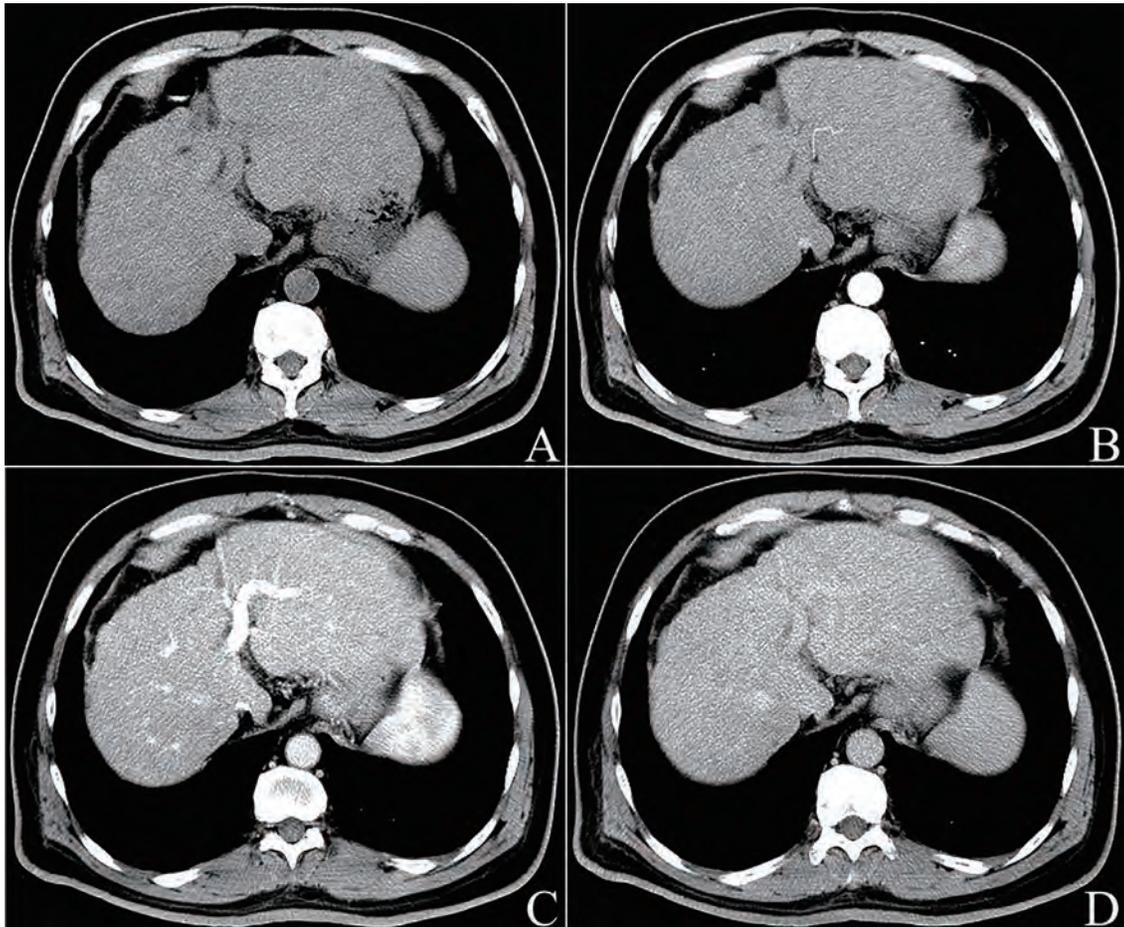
CT images of liver cirrhosis. Axial CT images show dysmorphism of the liver, including pronounced nodular irregularity of the liver surface, enlargement of the interlobar fissure, and hypertrophy of the left lobe (A–D). A precontrast CT image shows diffuse multiple nodules of <1 cm diameter and slight hyperdensity in the liver parenchyma (A), and contrast-enhanced isodense CT images in liver during the arterial (B), portal (C), and delayed phases (D). CT, computed tomography.
